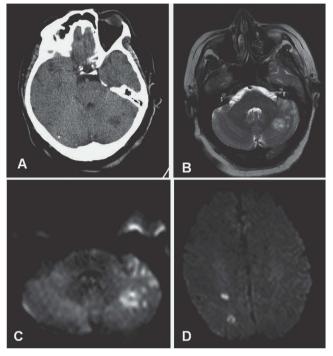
A: CT scan performed at the time of admission, showing parenchymatous hypodensity in the left cerebellar hemisphere. B, C and D: MRI scan performed on admission. B (T2-weighted image): signal hyperintensity in the left cerebellar hemisphere can be observed, which restricts diffusion (C), compatible with an acute ischemic stroke. At the supratentorial level (D), other acute lacunar infarctions can be observed in the right corona radiata.
